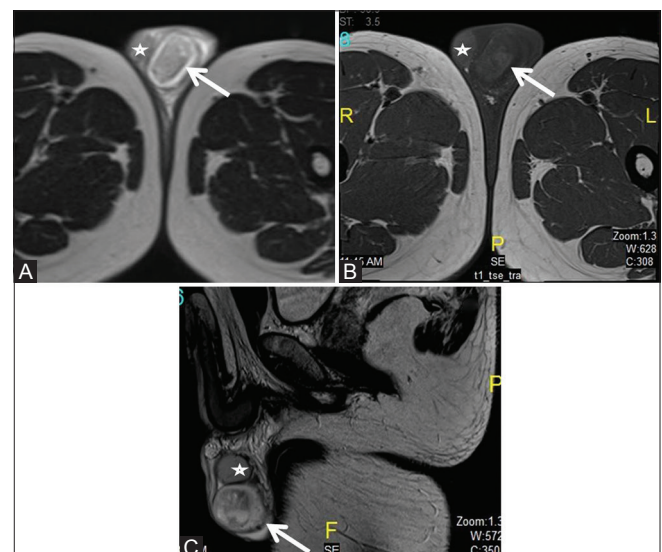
(A-C): (A) Axial T2-weighted MRI shows heterogeneous hyperintense mass (arrow) in the left hemiscrotum separate from the testis (asterisk). (B) Axial T1-weighted MRI shows heterogeneous isointense mass (arrow) in the left hemiscrotum separate from the testis (asterisk). (C) Sagittal T2-weighted MRI shows clearly the posteroinferior location of the mass (arrow) in relation to the left testis (asterisk) suggesting possible epididymal origin
